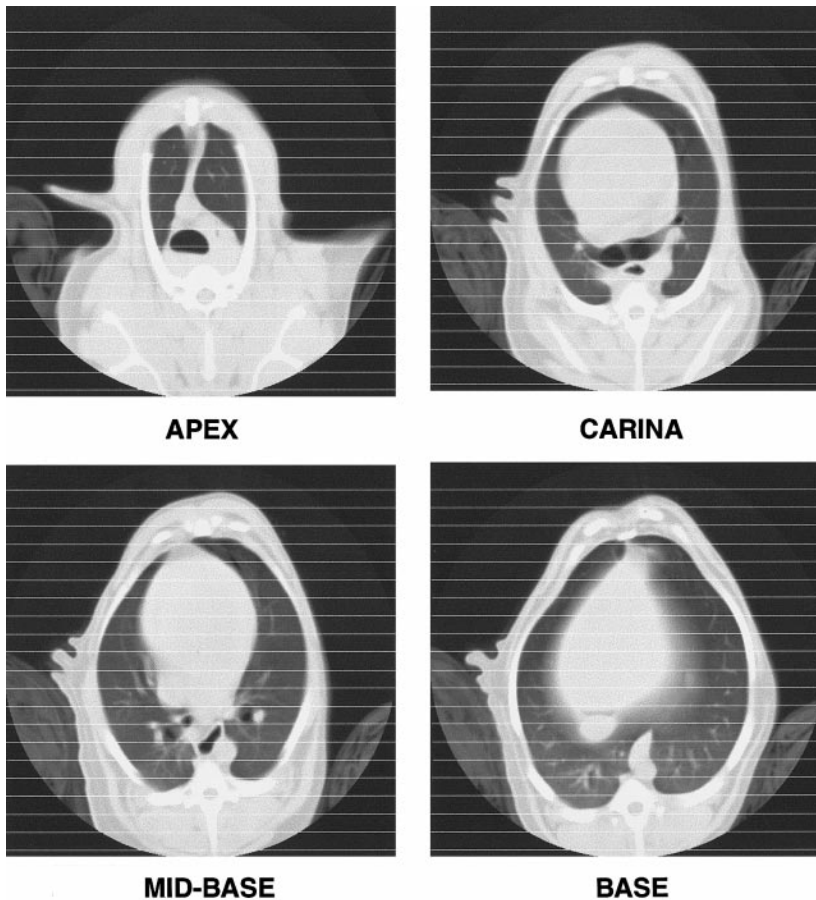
CT image locations for *protocol 1*.
